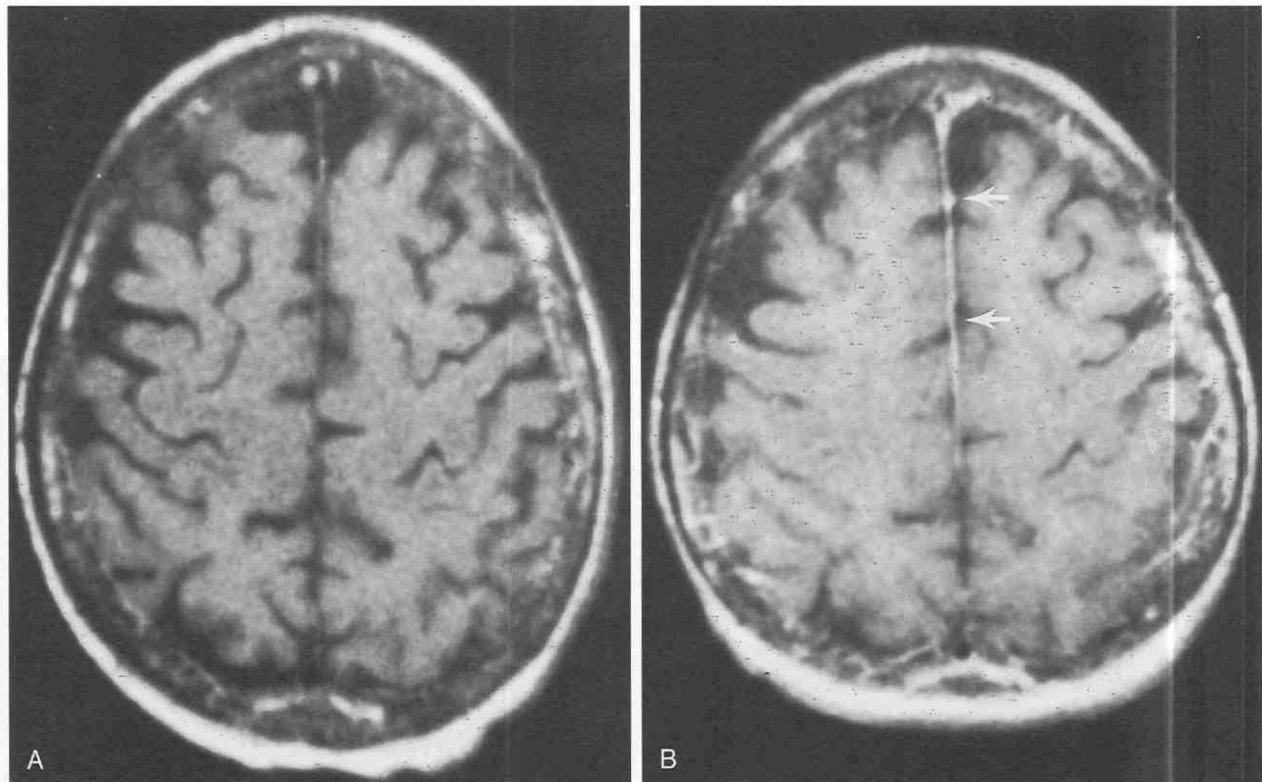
Effects of field strength on conspicuity of normal meningeal enhancement. A, Axial T1-weighted image acquired at 0.5 T immediately after injection of 0.1 mmol/kg gadolinium. B, Axial T1-weighted image acquired at 1.5 T, one day later, in the same patient, immediately after injection of the same dose of gadolinium shows more prominent enhancement of the falx (arrows) than in A. (From Meltzer CC, Fukui MB, Kanal E, Smirniotopoulos JG: MR imaging of the meninges: Part 1. Normal anatomic features and nonneoplastic disease. *Radiology* 201:297-308, 1996.)
